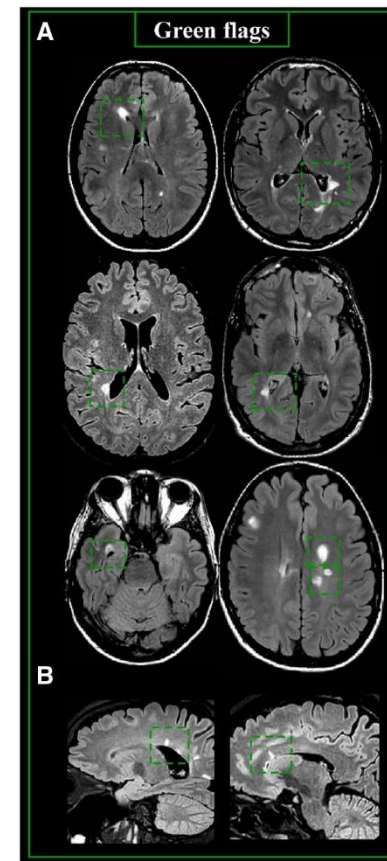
Typical MS MRI lesions.⁵
